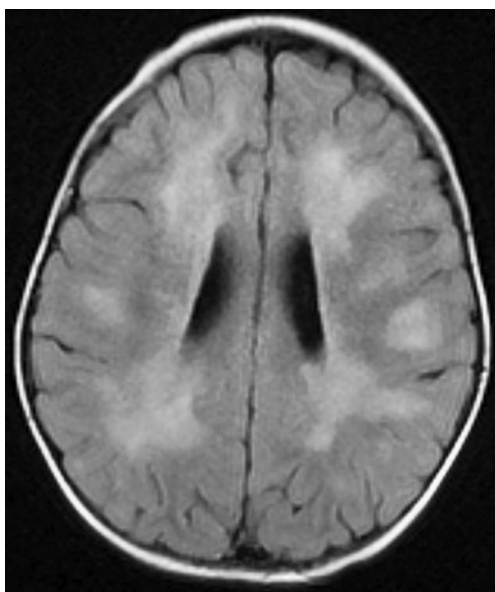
Axial T2-W FLAIR MR image shows extensive T2 signal prolongation within the periventricular white matter and centrum semiovale
